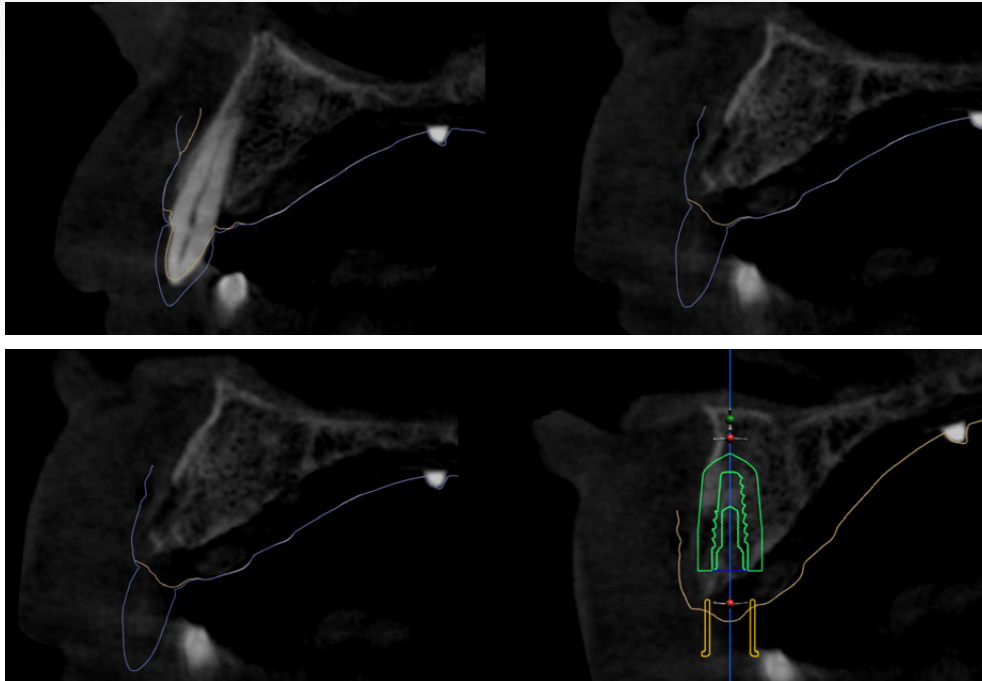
Intraoral surface scans (IOS) before and after removal of the original PFM bridge superimposed on the CBCT scan: this facilitates the planning of implant placement from a restorative perspective (restoration driven implant placement).
